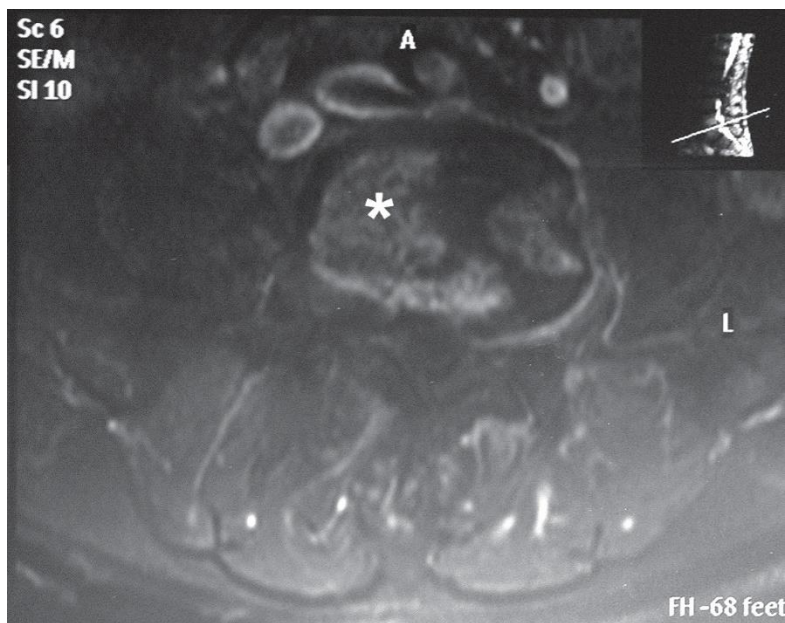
Axial lumbar spine MRI T1 image without gadolinium showing bony hyperintensity in keeping with osteomyelitis (white *)
